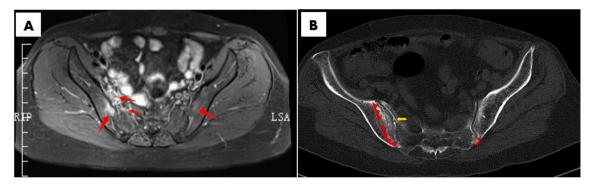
(A) MRI of the sacroiliac joints revealed bilateral sacroiliitis. (B) Representative computed tomography (CT) images of in our case. Hyperosteogeny and sclerosis can be seen on the ilium surface of bilateral sacroiliac joints, and the joint surface of both sides was rough (red arrows). Insect erosion like bone destruction can be seen on both sides (yellow arrows), especially on the right.
